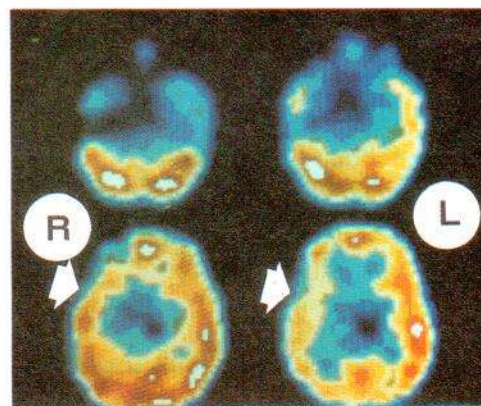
10-year-old boy with juvenile neuronal ceroid lipofuscinosis. SPECT showed a large area of hypoperfusion in right frontal and temporal lobes.
